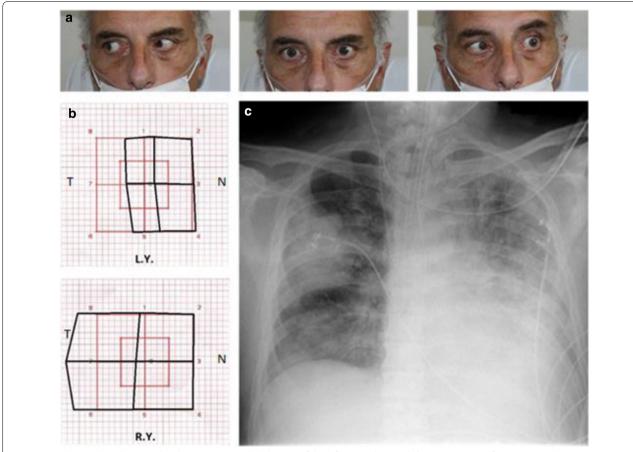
a Ocular motility photographs, showing impaired abduction of the left eye (right panel). b Measurements from sequential Lancaster red-green tests, confirming the impairment of abduction in the left eye. T temporal, N nasal. c An X-ray of the chest revealing the bilateral diffuse whiteout characteristic of acute respiratory distress syndrome
